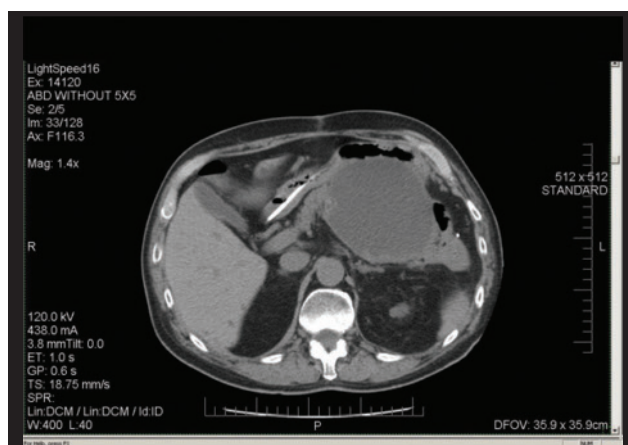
CT scan image showing a large pancreatic pseudocyst compressing the stomach with resulting gastric outlet obstruction. Note nasojejunal tube traversing the stomach.
